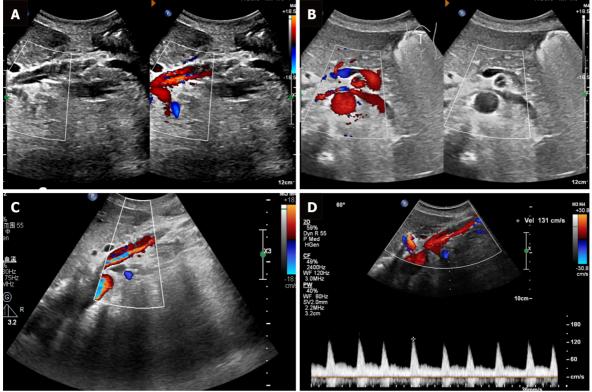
Doppler ultrasound showed the blood flow of the superior mesenteric artery dissection. A: Ultrasonic longitudinal view showed the flow at the opening of the superior mesenteric artery dissection (SISMAD); B: Ultrasonic transverse view showed the flow at the opening of the SISMAD; C: Color Doppler flow imaging showed the true and false lumens of the SISMAD; D: True lumen velocity of superior mesenteric artery dissection was measured by spectral Doppler.
